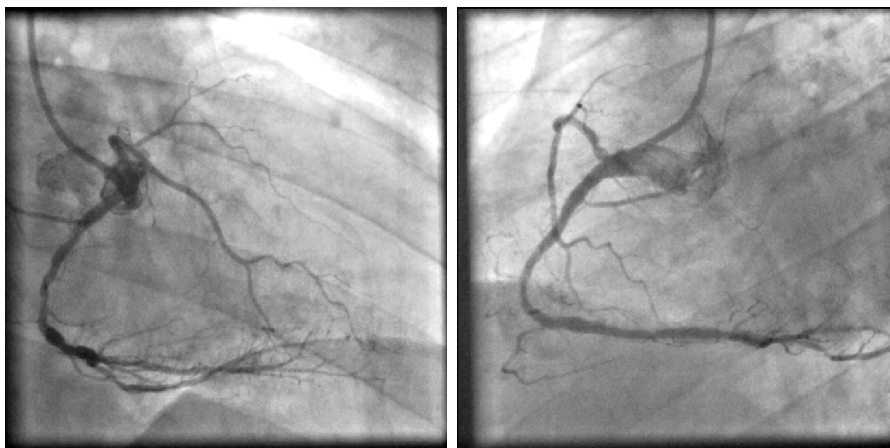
Biplane X-ray angiograms of coronaries (left: view 1; right: view 2)
